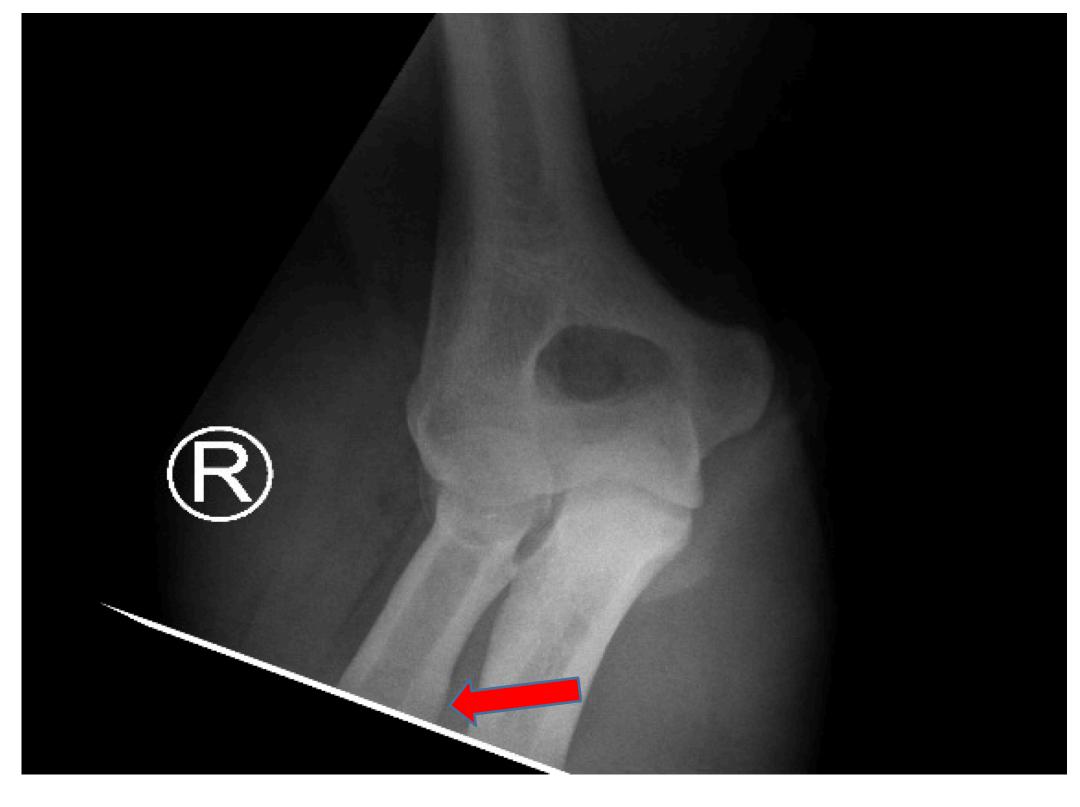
X-ray of Right Elbow, AP view, Red arrow- Radial Tuberosity
